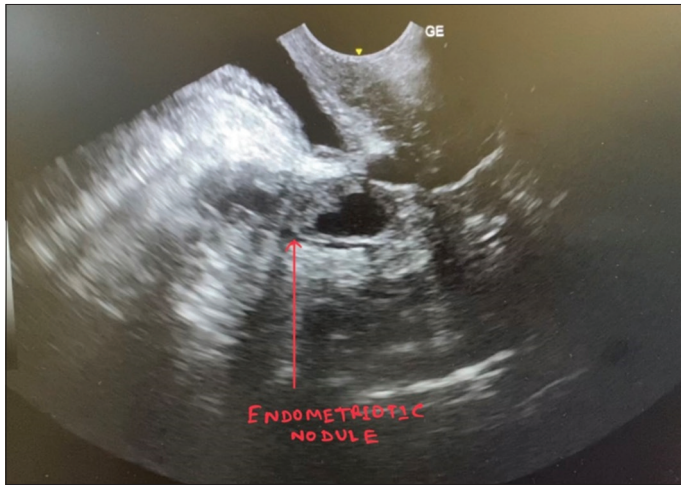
Transperineal ultrasound showing multi-loculated complex cystic lesion
